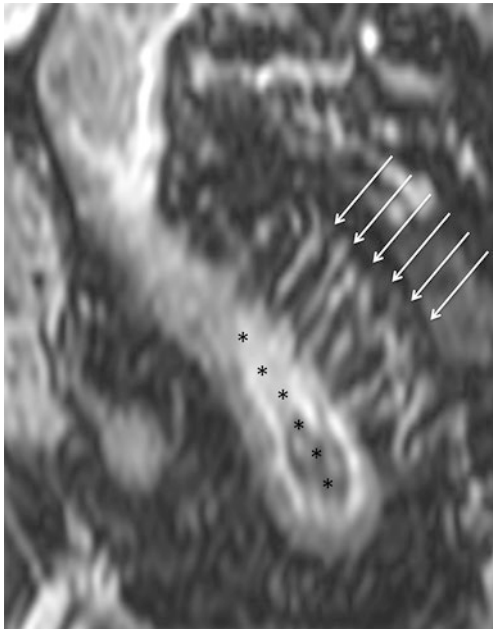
“Comb sign” in Crohn’s disease. Coronal GE T1-weighted and fat-saturated image, obtained after i.v. injection of gadolinium. Ectatic vasa recta (arrows) supplying a diseased bowel loop (asterisks)
